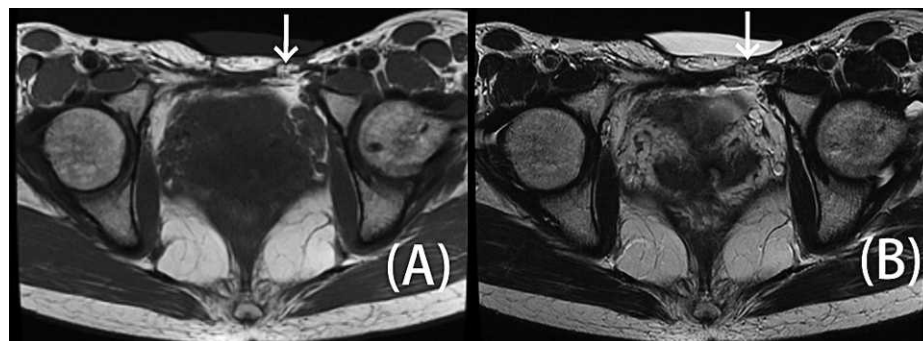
Abdominal MRI shows a heterogeneous mass in the left abdominal wall with high signal intensity on (A) T1W1 and (B) T2W1 images (white arrow).
